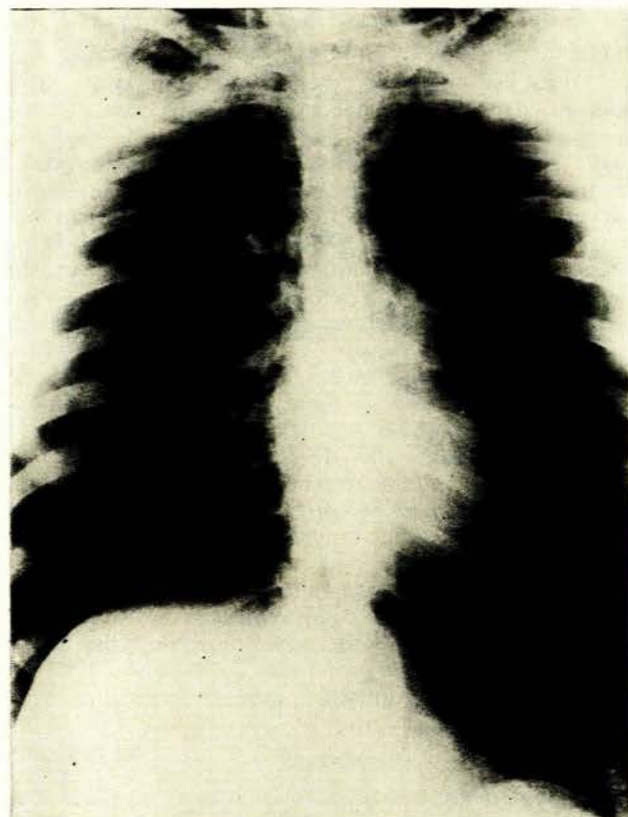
Chest X-ray of case 2 before insertion of a needle.
